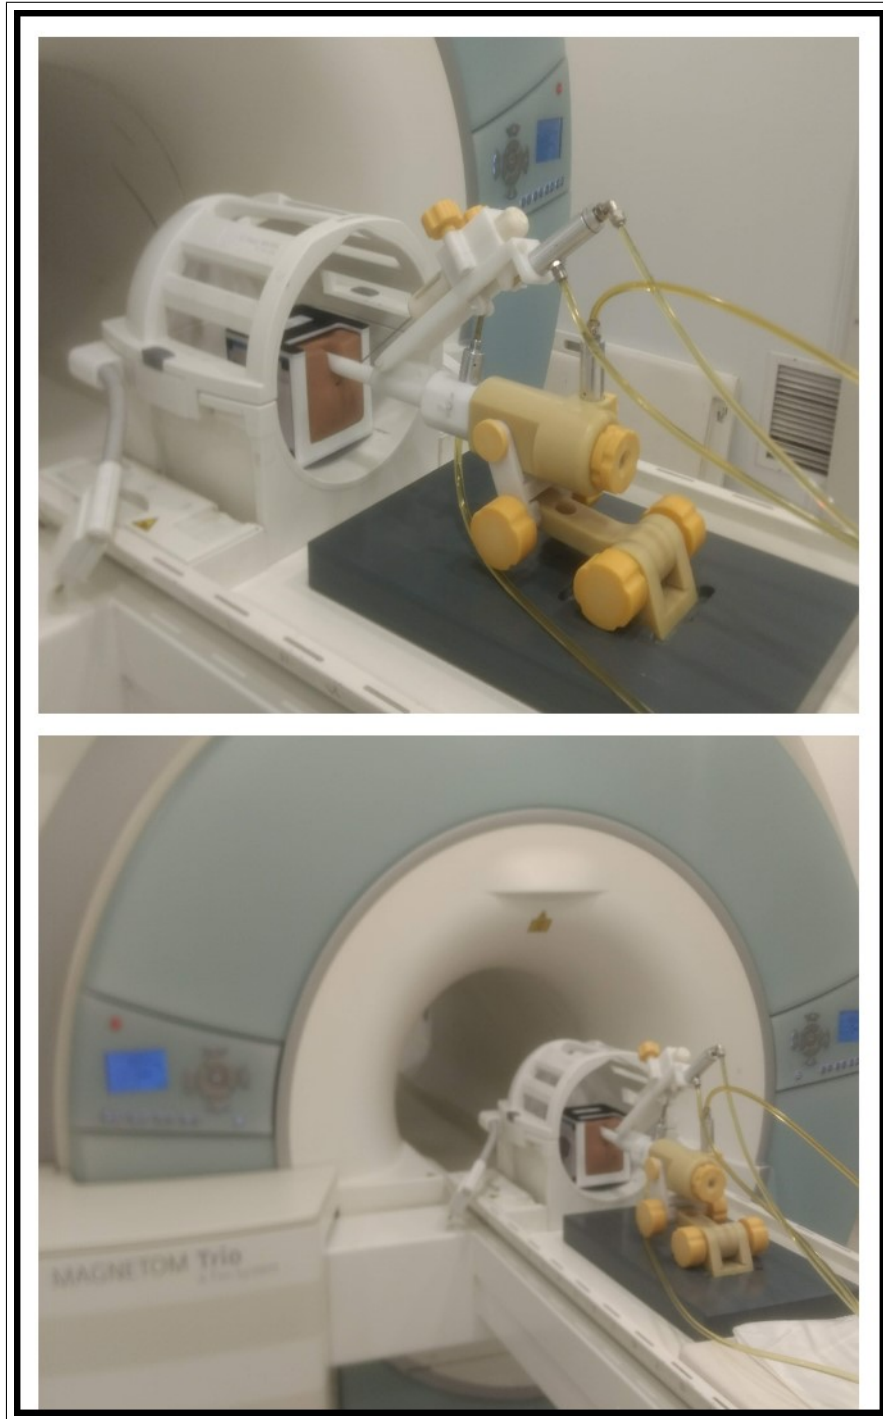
Experimental setup under 3T MRI
